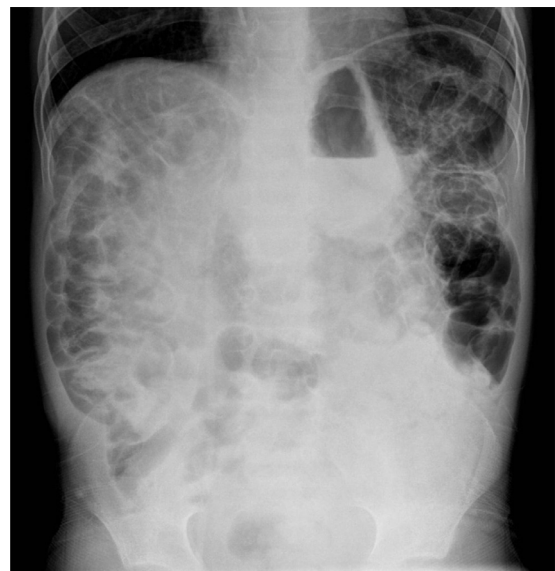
Plain abdominal radiograph shows an intramural gas collection of the cecum and colonic wall suggestive for diffuse pneumatosis cystoides intestinalis.
